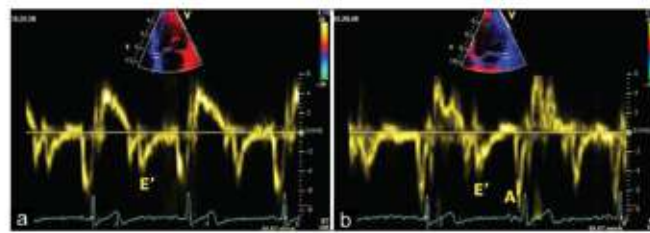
Mitral annular velocities on pulsed-wave tissue Doppler imaging; (a) medial annulus, (b) lateral annulus
